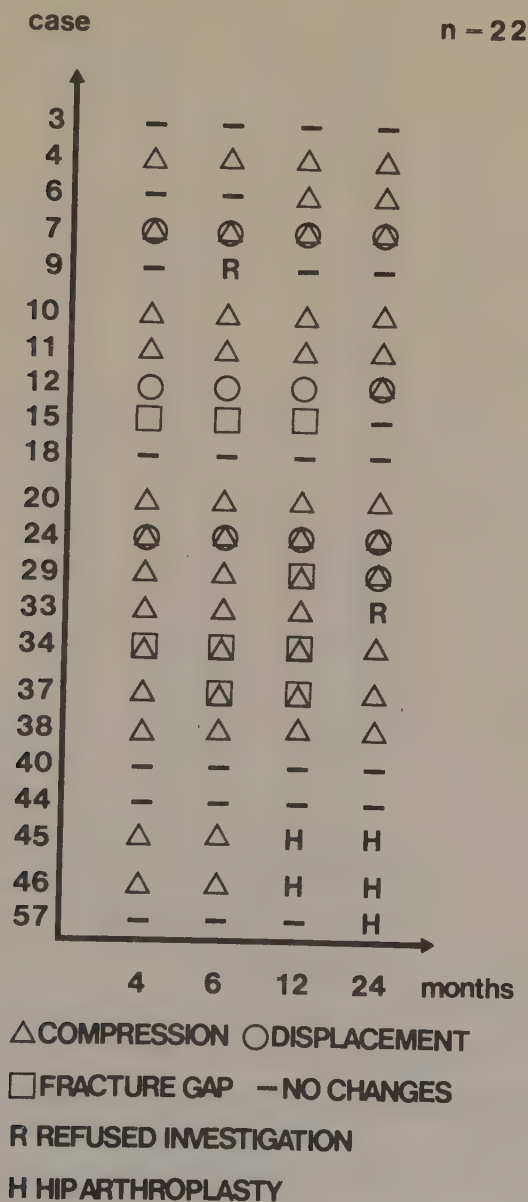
Radiographic changes in the femoral neck in 22 necrosis cases
